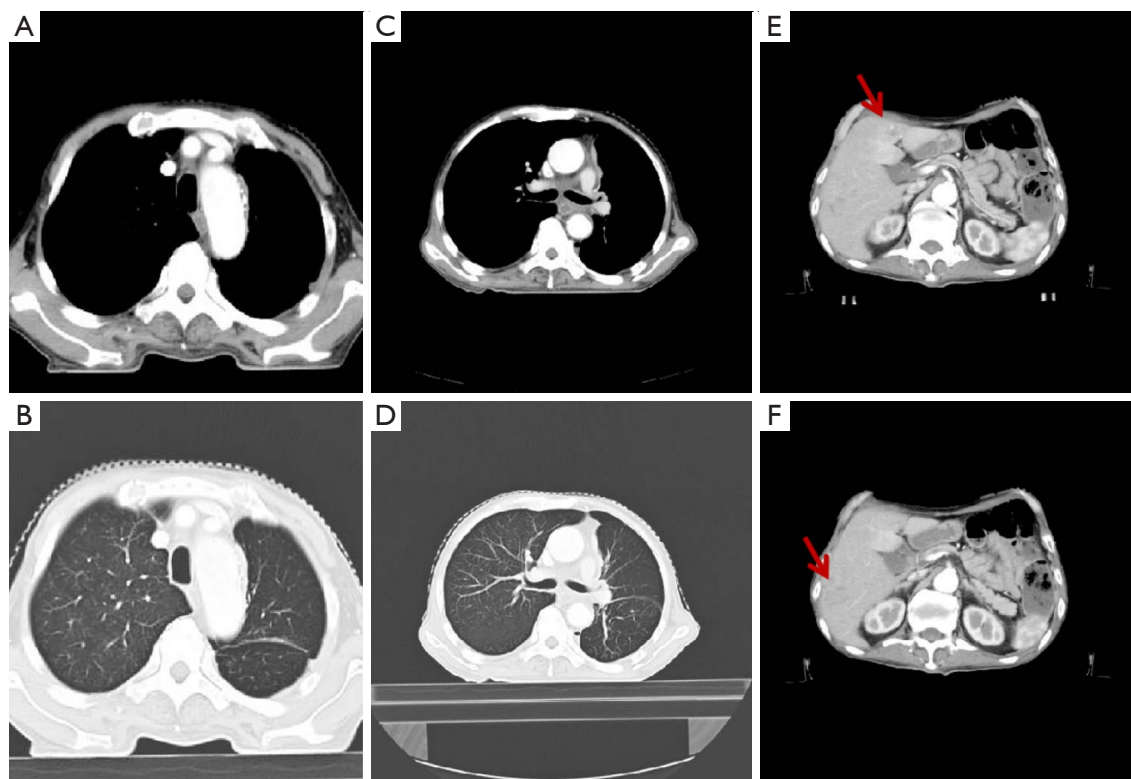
Chest CT after the treatment of envafolimab. (A-D) The occupying area in the left hilar was reduced, and the bronchial obstruction was distinctly alleviated. (E,F) Liver metastasis showed no significant improvement. The arrows indicated the liver metastatic lesions. CT, computed tomography.
